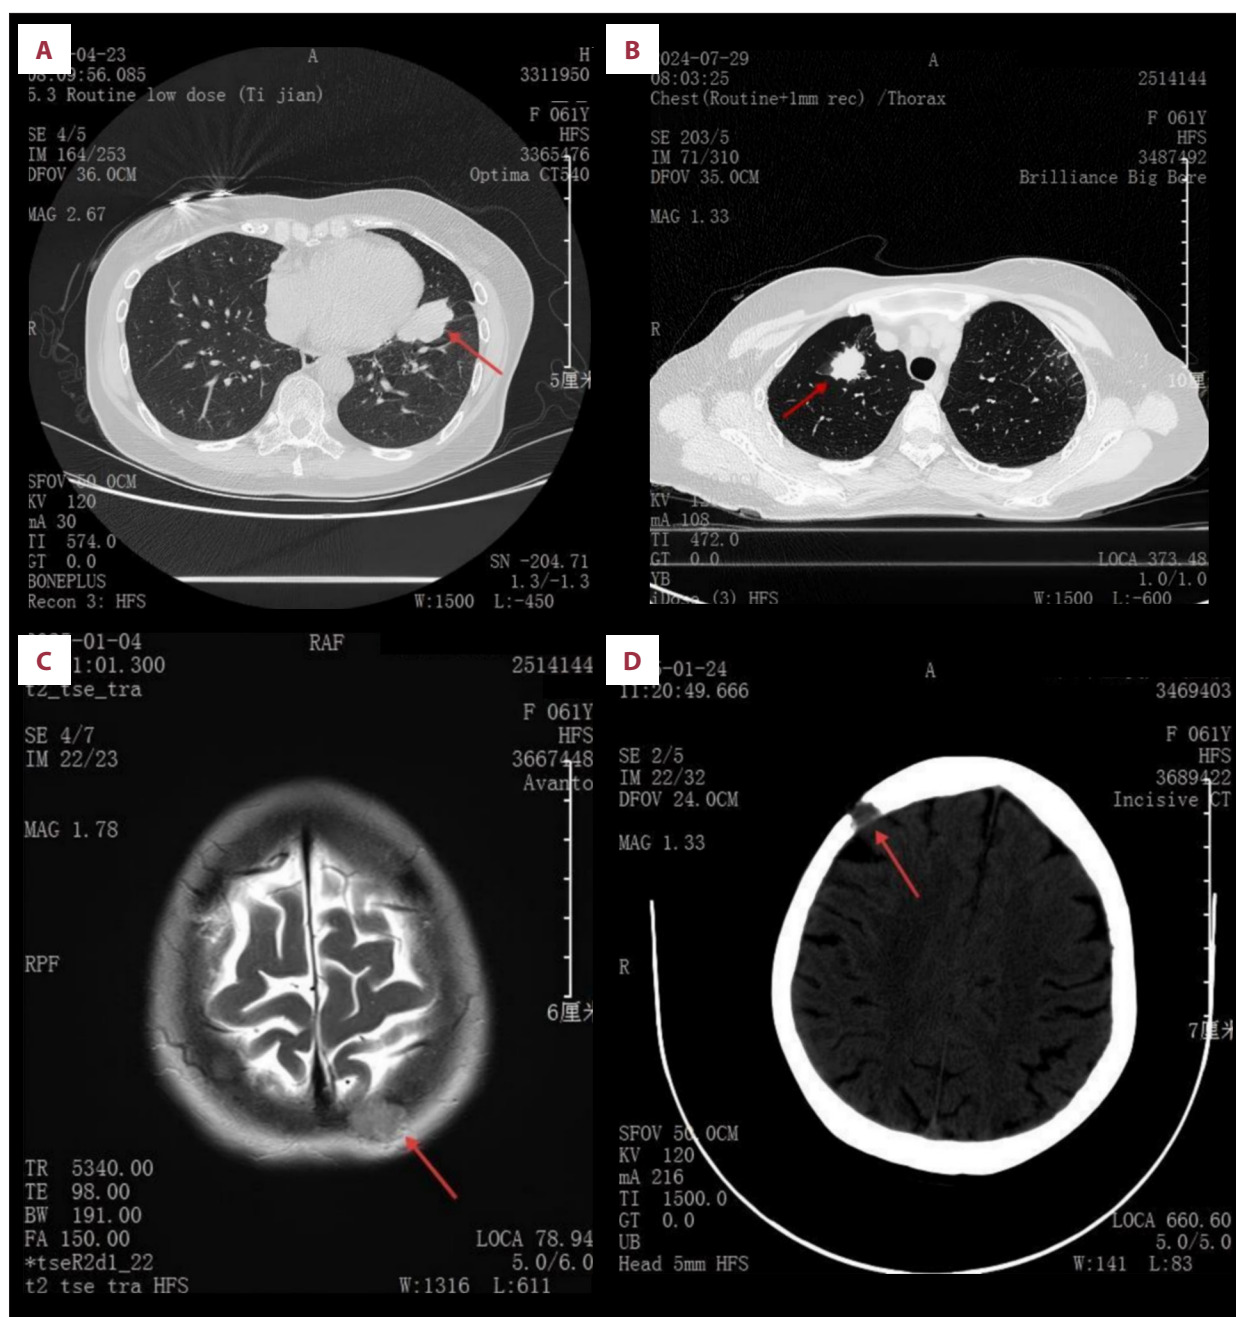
Imaging of multi-system metastases during the terminal stage. (A) Chest computed tomography (CT) without contrast (April 2024) shows multiple solid masses in both lungs: the lesion in the left lower lobe measures approximately $35 \times 22 \text{ mm}^2$, accompanied by lobulation and pleural indentation. (B) Chest CT without contrast (July 2024) reveals an enlarged nodule in the right upper lobe measuring approximately $12 \times 18 \text{ mm}^2$. (C) Brain magnetic resonance imaging without contrast (January 2025) shows multiple nodular abnormal signals in the skull bones bilaterally, suggestive of metastatic lesions. (D) Brain CT without contrast (3 weeks later) confirms the bilateral presence of multiple metastatic tumors in the skull bones. Red arrows indicate the metastatic tumors.
